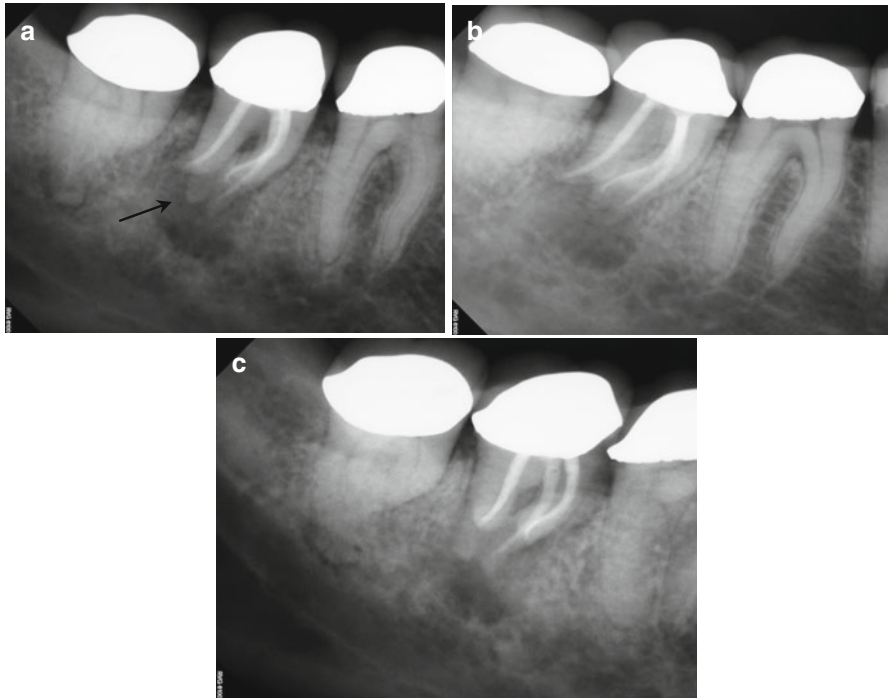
(a–c) Right-angle and off-angle radiographs reveal a large PAA at the apices of tooth #30. There is a suggestion of an auxiliary root in (a) (*black arrow*), but its origin within the chamber and buccal-lingual position is not disclosed in any of the conventional images. (d) The axial view in the scan 2 mm apical to the CEJ confirms the presence of a second canal in the distal root, 2 mm lingual to the DB (*white arrow*). The coronal section reveals a sharp dilacerations of this root toward the buccal as it nears its terminus (*red arrow*); this change in direction will be explained in the next. (e) The axial view 2 mm from the terminus shows the DL root fusing with the ML root (*white arrow*), but their respective canal spaces do not join. At this level, the canal assumes a more linear path (*red arrow*). (f) The colorized 3-D coronal section highlights the juxtaposition of the DB and DL roots (*red arrow*) as well as the extent of the PA lesion and the thinning of the lingual cortical plate (*white arrows*). (g) Working length radiograph with files in the DB and DL canals. The gutta-percha is yet to be removed from the mesial canals (the radiopaque pin in the image is a 5 mm reference in the film holder). (h) Final radiographs of the completed retreatment. Note the overlapping of the mesial roots and the DL root. (i) 12-month recall radiographs; the lesion appears to be resolved, but overlying structures can mask underlying spaces. (j) 12-month CBCT scan demonstrates complete resolution after a thorough review of all the slices in all planes. This slice level corresponds to the location of the largest dimension of the lesion preoperatively. (k) A comparison of the preoperative (*top*) and 12-month postoperative (*bottom*) coronal and sagittal slices at almost identical levels, exhibiting complete resolution of the lesion
